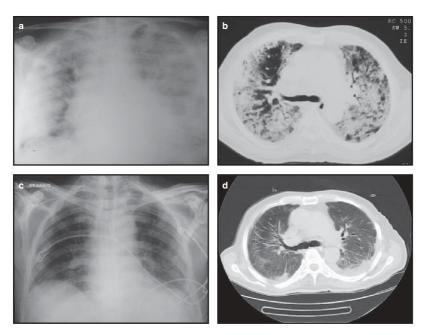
This 69-year-old man was under treatment with amiodarone 200 mg/day for the previous 4 months because of several episodes of sustained ventricular tachycardia post-acute myocardial infarction. The patient developed fever, dry cough, haemoptysis and progressive dyspnoea with severe respiratory insufficiency that required mechanical ventilation. (a) The posteroanterior chest radiograph disclosed diffuse bilateral confluent air-space infiltrates. (b) Conventional 10 mm collimation CT scan of the chest confirms the presence of a diffuse air-space filling process consistent with acute respiratory distress syndrome. Amiodarone was withdrawn. A surgical lung biopsy disclosed overlapping features of chronic organizing pneumonia and diffuse alveolar damage (acute fibrinous and organizing pneumonia type) compatible with amiodarone-induced acute lung toxicity. High-dose corticosteroids were added and after a complicated clinical course, the patient recovered and was extubated. (c) Resolution of pulmonary opacities 45 days after discontinuation of amiodarone and corticosteroid treatment. (d) A synchronous CT of the chest demonstrates minimal left pleural effusion and residual patchy parenchymal changes in the right lung (reproduced by courtesy of Dr K. Pontikis and Dr M. Theodorakopoulou, 2nd Department of Critical Care, National and Kapodistrian University of Athens. Greece).
